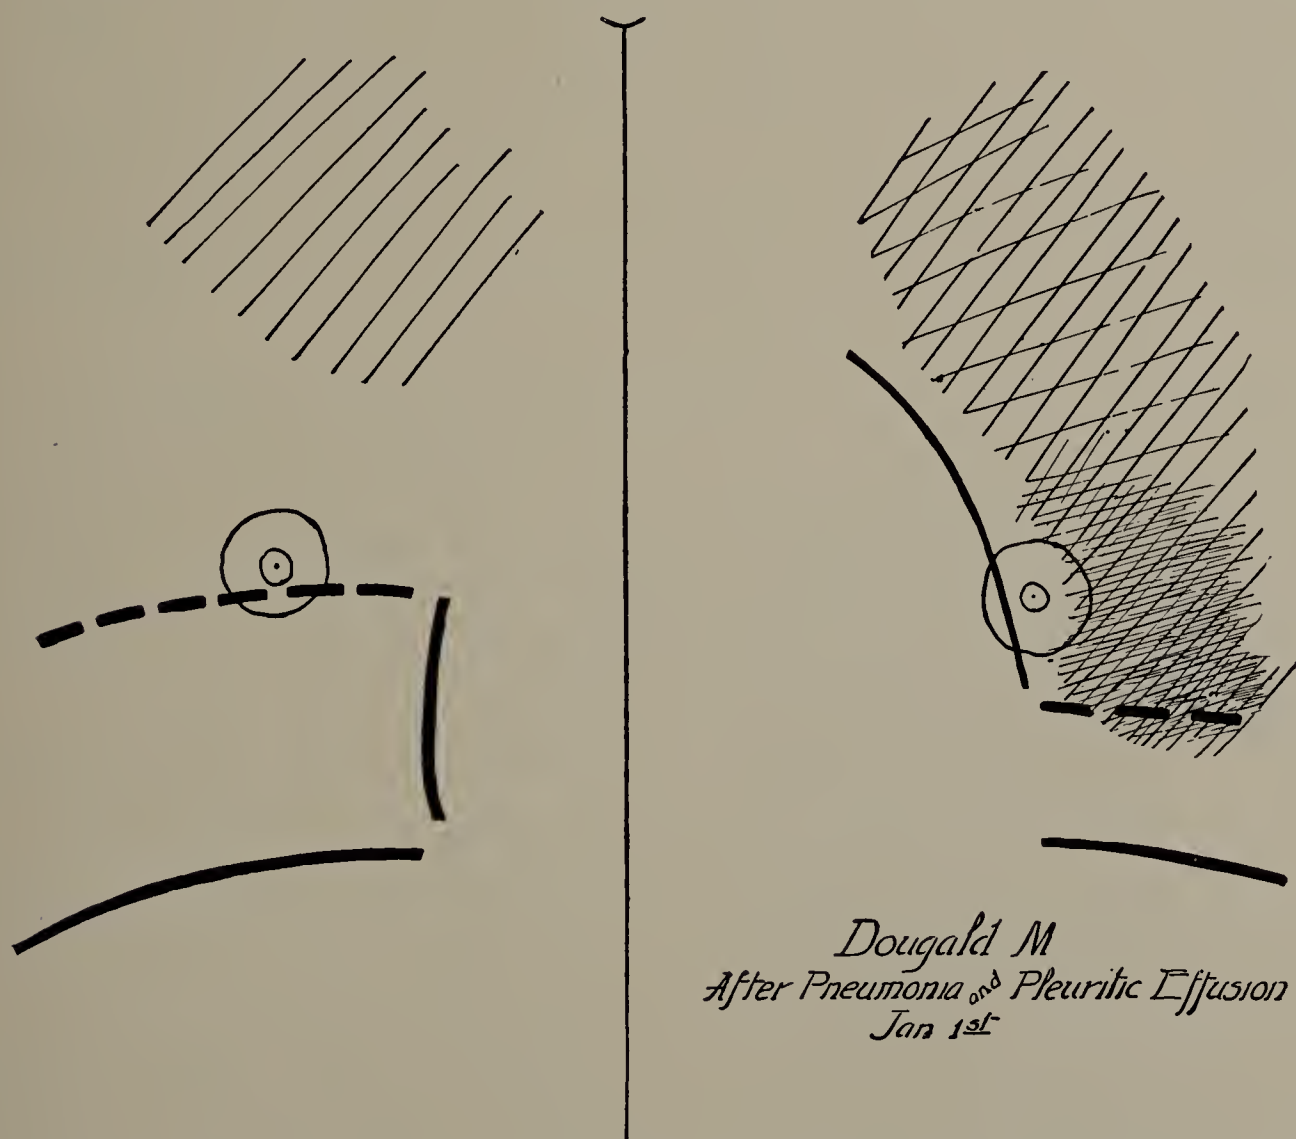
Dougald M. January 1, 1900. Second X-ray tracing. (Compare with first tracing of this patient, Fig. 137). Improvement at right apex and increase in excursion of diaphragm on that side. On the left side the lung is less dense and there is no pleuritic effusion, as the diaphragm lines can now be well seen. (Cut one-third life size.)
